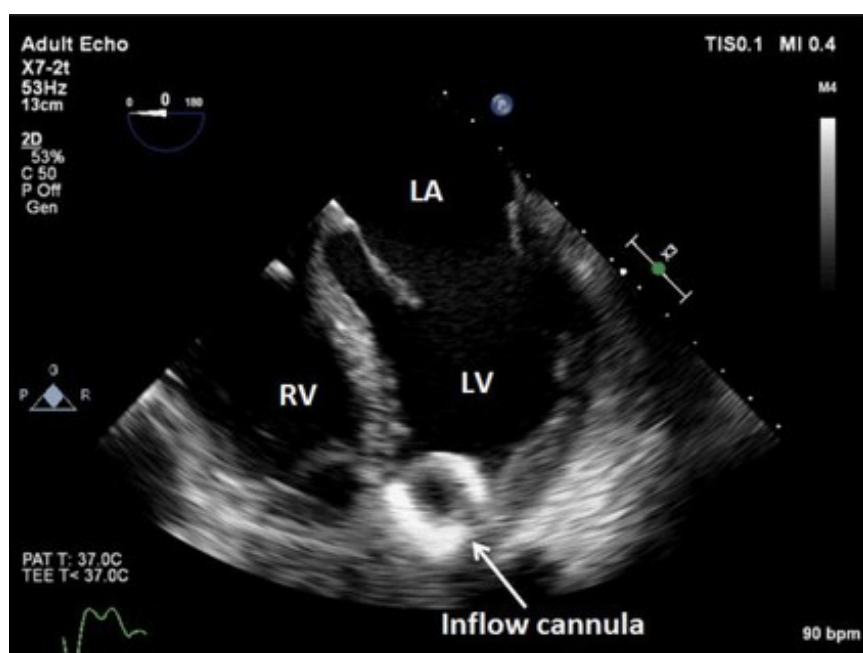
Trans-esophageal echocardiography showing movement of interventricular septum to the left with inflow cannula of LVAD in situ (94).
